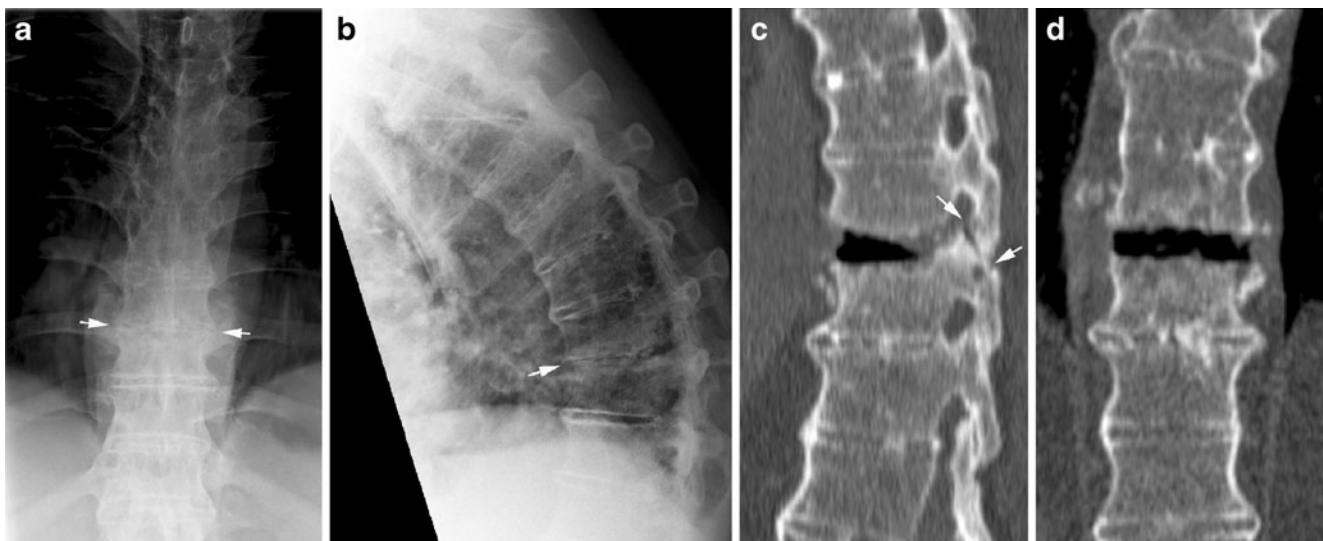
Spinal fracture in AS. (a) AP and (b) lateral radiograph of the thoracic spine in a 64-year-old man with advanced AS and increasing back pain over 4 weeks. The lateral view demonstrates a slight malalignment at the anterior aspects of the vertebral bodies of Th9 and Th10, and the iv is irregularly narrowed on the AP view, all
